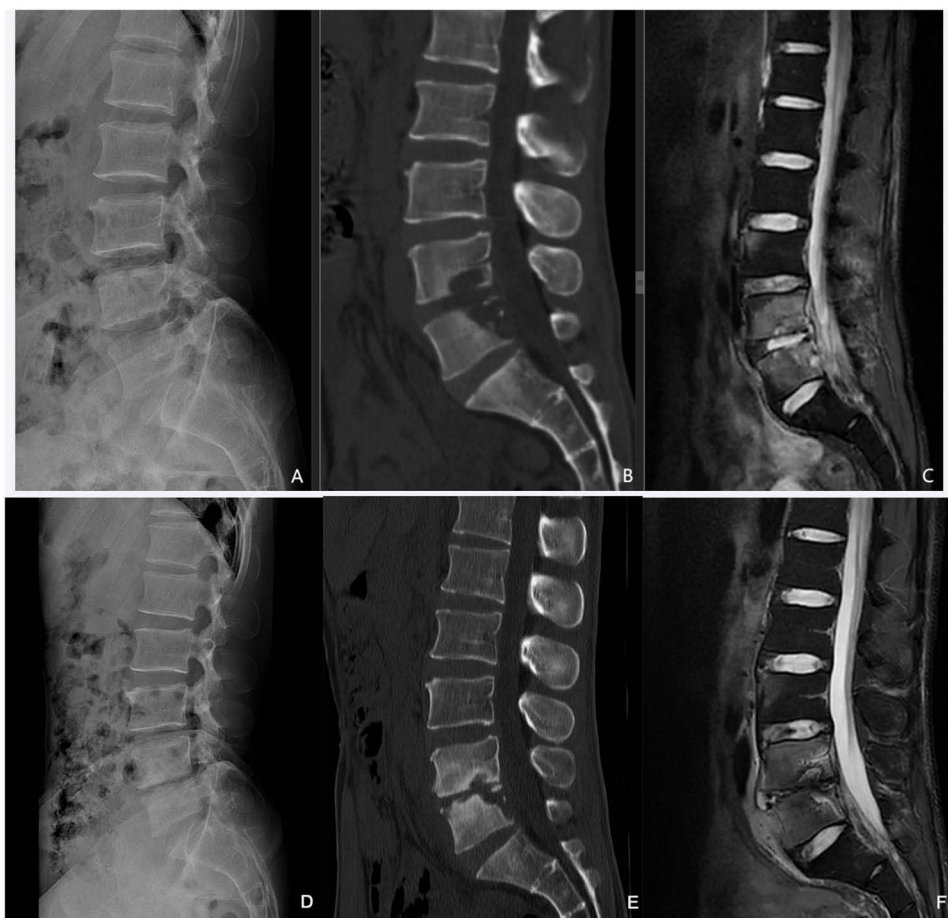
A 35-year-old male was diagnosed with advanced BS. She received antibacterial treatment. Imaging examinations were performed after 7 months. X-ray diagnosis showed degenerative lumbar bone disease (A); sagittal CT scan reconstruction demonstrated bone destruction under the endplate of the lumbar vertebrae 4 and 5, with clear boundaries and no sclerotic edges (B); MRI scan with fat-suppressed T2 weighted image (T2WI) sequence showed high signal bone destruction under the endplate of lumbar vertebrae 4 and 5, and surrounding bone marrow edema, indicating spondylodiscitis (C); Follow-up lateral lumbar X-ray at 7 months after antibiotic therapy showed narrowing of the L4–L5 intervertebral space, slightly reduced bone destruction, and increased sclerotic changes within the affected vertebrae (D); Follow-up sagittal CT scan reconstruction of the lumbar spine at 7 months after antibiotic therapy demonstrated narrowing of the L4–L5 intervertebral space, mildly decreased bone destruction, and more extensive sclerotic changes in the affected vertebrae (E); Follow-up sagittal T2-weighted MRI of the lumbar spine at 7 months after antibiotic therapy revealed narrowing of the L4–L5 intervertebral space, reduced bone destruction with a distinct low-signal sclerotic rim, decreased bone marrow edema in the affected vertebrae, but slightly increased granulation tissue (hyperintense signal) anterior to the L5 vertebral body (F).
